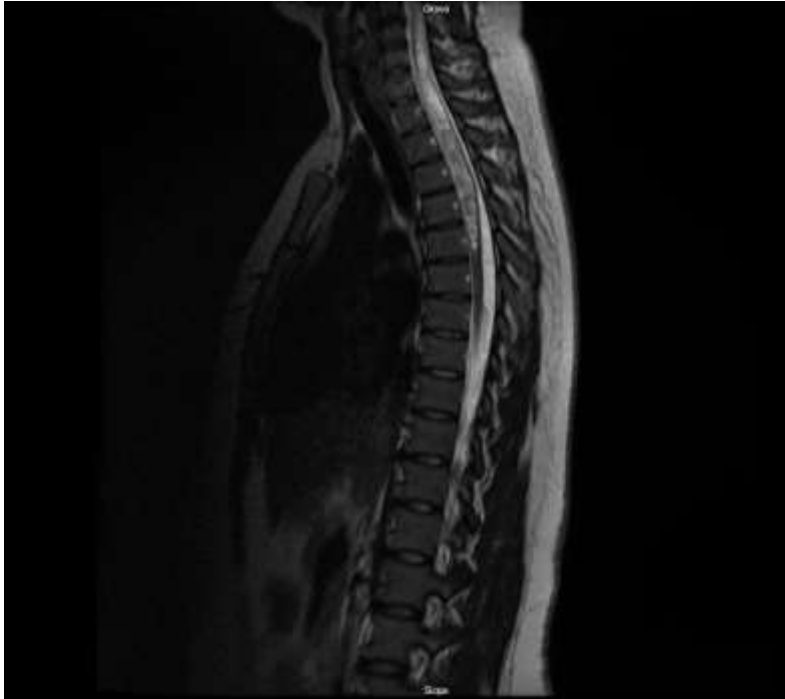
MRI of the thoracic spine (during hospitalization) – within the upper part of the thoracic segment, the syringomyelic cavity is visible up to the C2 region of the cervical segment; lower cavity limit at Th6 level [authors' material]
